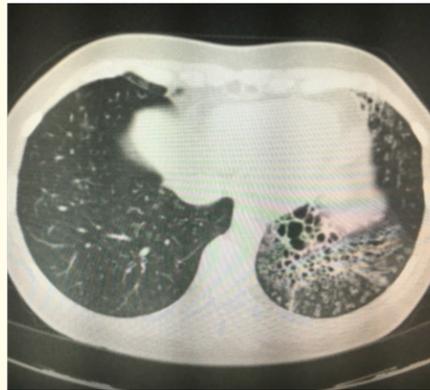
Images of high-resolution computed axial tomography (HRCT).
